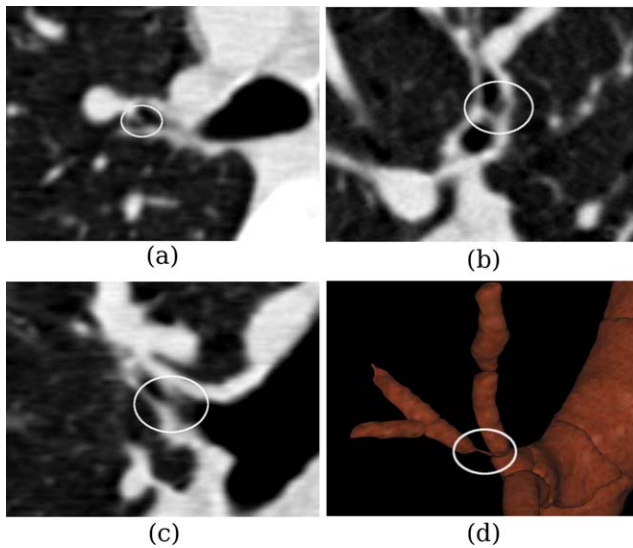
HRCT of an asthmatic patient displaying an uncharacteristic airway stenosis in the RUL (third generation). The region of interest is marked with a circle and is shown from different perspectives: a) transverse, b) coronal, c) sagittal, and d) 3D reconstruction.
